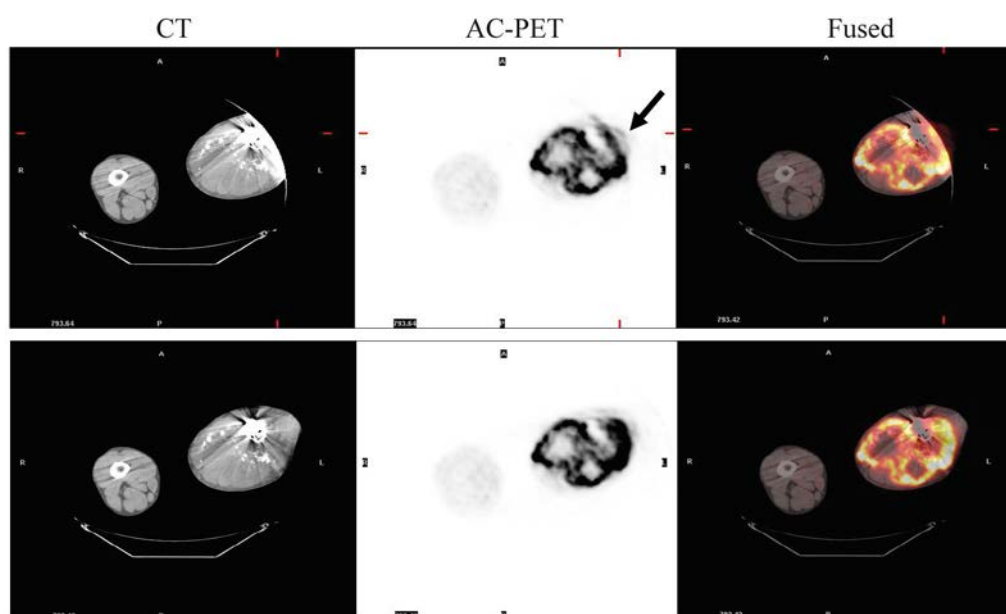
Upper panel: whole body FDG-PET/CT study of a patient with the diseased leg positioned off-centre, resulting in truncation artefacts in the area of the osteosarcoma. Lower panel: the same images following truncation correction with extended field of view reconstruction. From left to right: transaxial CT, AC-PET and fused AC-PET/CT. AC: attenuation corrected.
